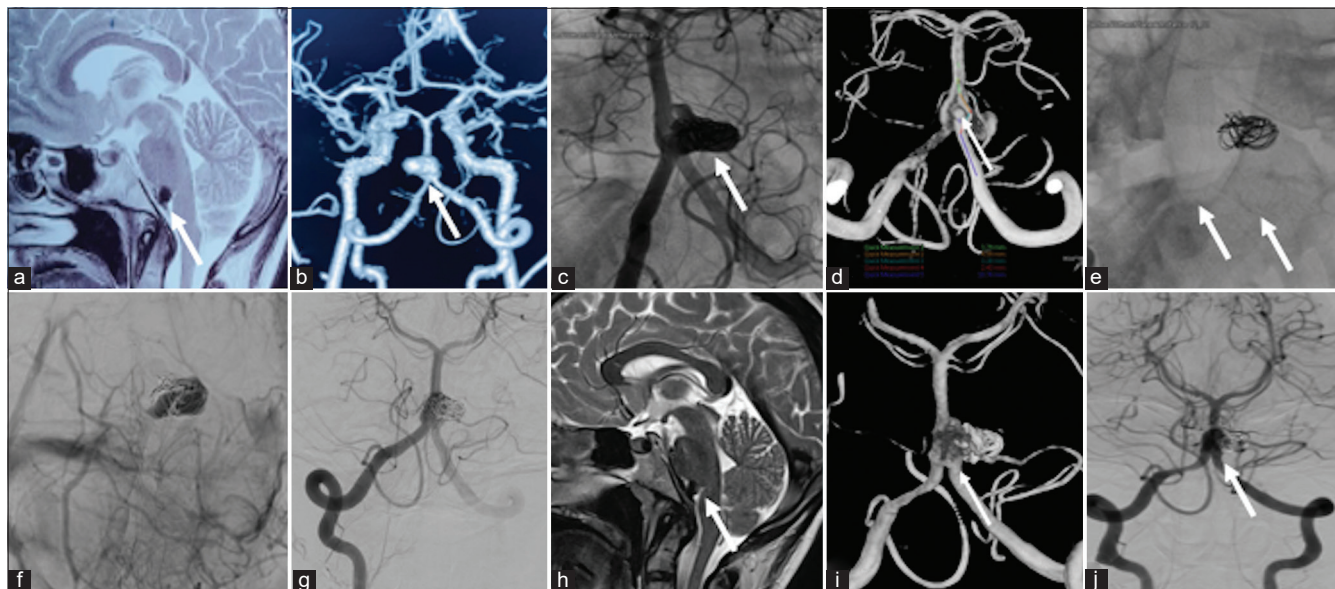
Magnetic resonance angiography (MRI) and digital subtraction angiography (DSA) images showing the aneurysm and reverse Y stenting at the vertebrobasilar junction (VBJ). (a-d) shows the Sagittal Brain MRI, MRI angiography and DSA respectively, depicting the aneurysm at the VBJ (white arrows). (e-g) depicts immediate post-treatment images showing the reverse Y stenting with coiling and stasis within the aneurysm (white arrows). (h) shows follow-up MRI and (i and j) shows followup DSA after 3 months depicting resolution of the small aneurysm in the left limb of the fenestration and no significant change in the size of the larger aneurysm (white arrow).
